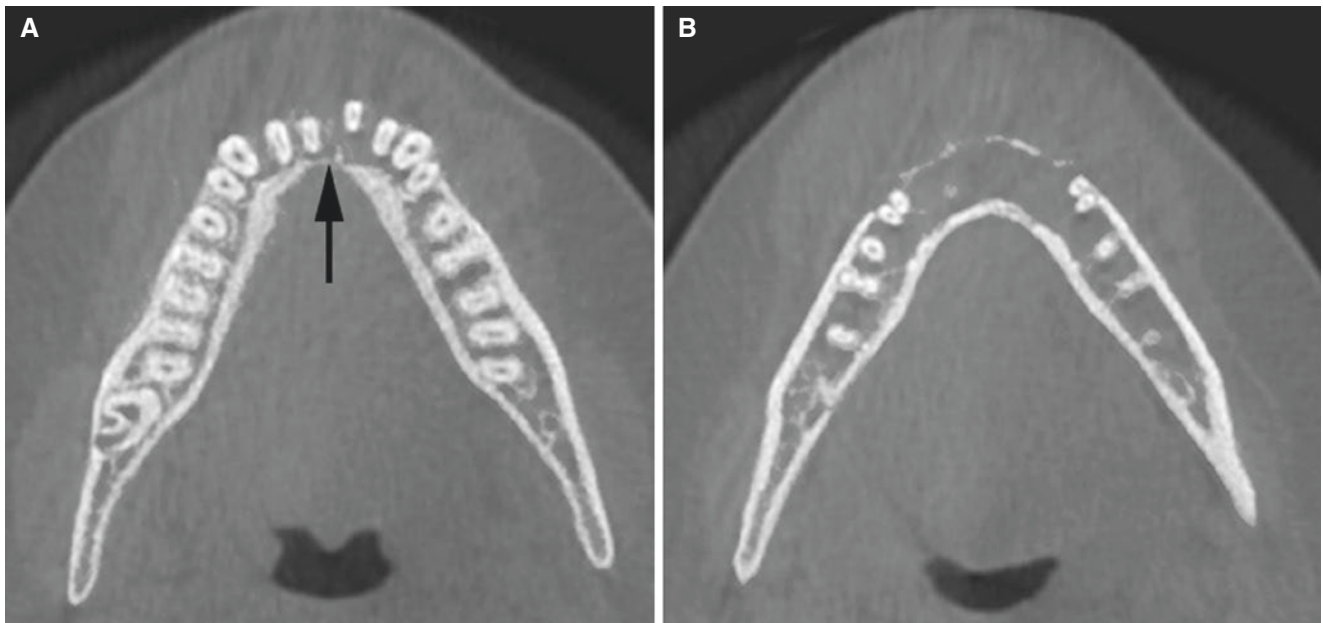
Ewing sarcoma, mandible; 17-year-old female with mass in the anterior part of the mandible. Two axial CBCT images show severe bone destruction in the anterior mandible (*arrow*). For more examinations and diagnostic information of this patient, see Fig. 4.31
